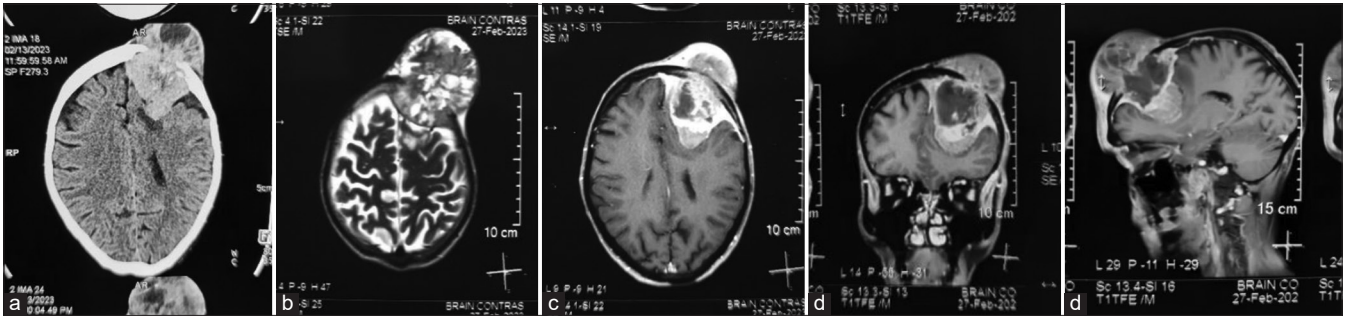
Pre-operative images: (a) Non-contrast computed tomography head showing the lesion, (b) Magnetic resonance imaging (MRI) brain T2-weighted image showing heterogeneously hyperintense lesion, (c-e) showing contrast-enhanced MRI images in axial, coronal and sagittal views
